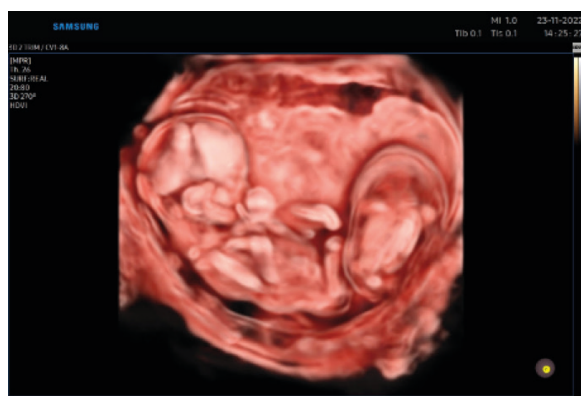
Three-dimensional ultrasound showing “pump” fetus and acardiac fetus.
